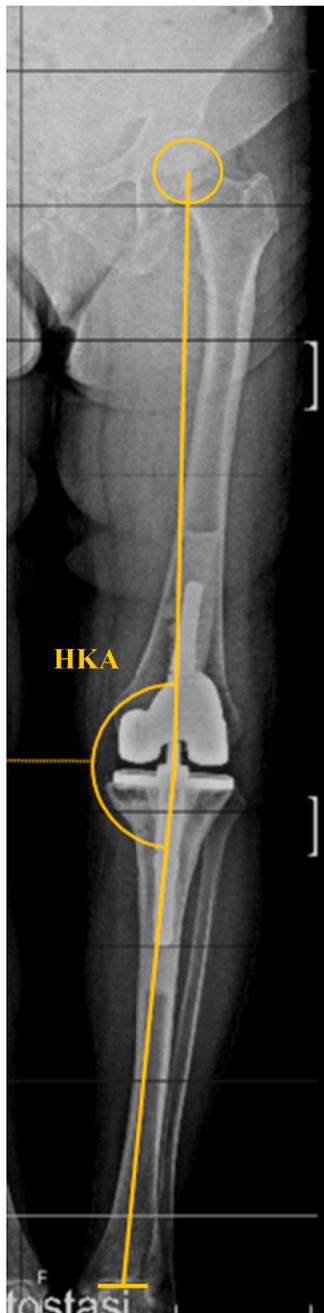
Radiographic assessment of postoperative measurements, HKAa hip-knee-ankle angle.
